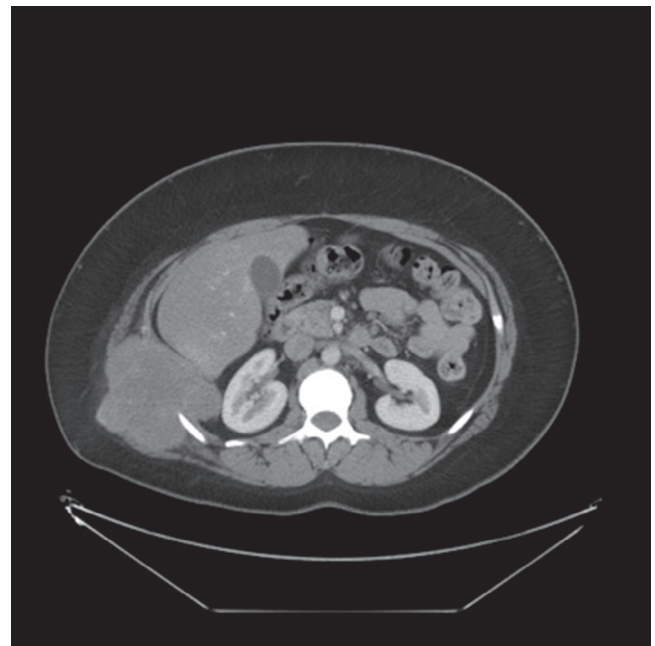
■ CT scan of a right posterior Ewing tumor.
